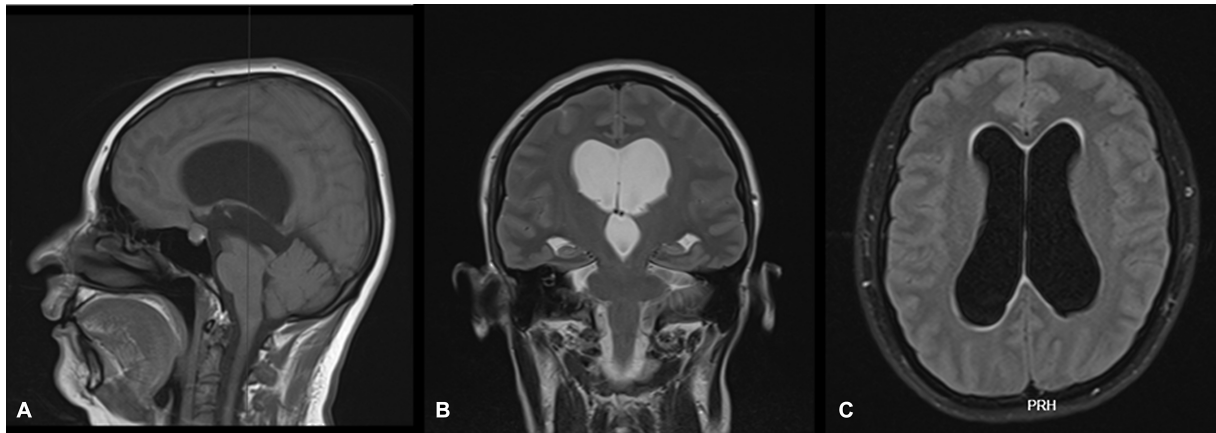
(A) MRI sagittal T1 sequence showing marked dilation of the lateral and third ventricles. (B) Coronal T2 sequence, which confirms obstructive hydrocephalus as evidenced by aqueductal stenosis. (C) Axial T2 fluid-attenuated inversion recovery (FLAIR) sequence reveals mild transependymal migration visible surrounding the frontal horns of the lateral ventricles.
